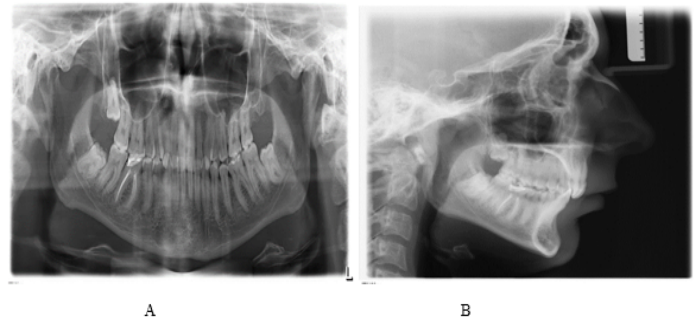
a) Panoramic radiograph at the start of treatment; b) Cephalometric radiograph at the start of treatment
